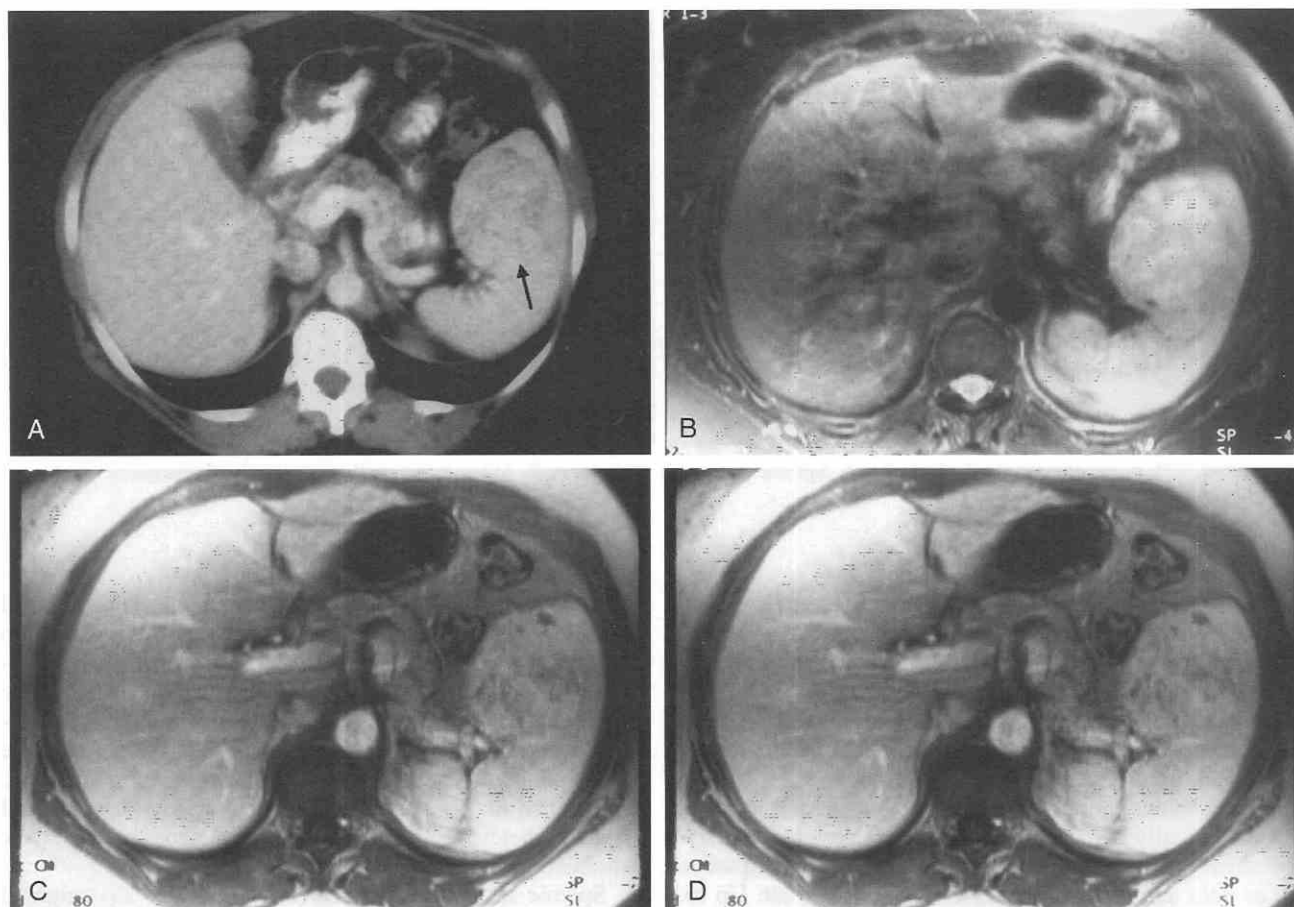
Hemangioma of the spleen, demonstrated on both CT and MRI. A. CT scan obtained during the arterial phase shows a heterogeneously enhancing hemangioma in the spleen (arrow). B. T2-weighted MR image demonstrates the heterogeneously high signal of the hemangioma. C. T1-weighted, portal venous phase MR image obtained after IV administration of gadolinium demonstrates heterogeneous enhancement of the hemangioma, similar to the CT appearance on A. D. T1-weighted MR image obtained 5 minutes after IV administration of contrast agent image demonstrates near-complete enhancement of the hemangioma.
